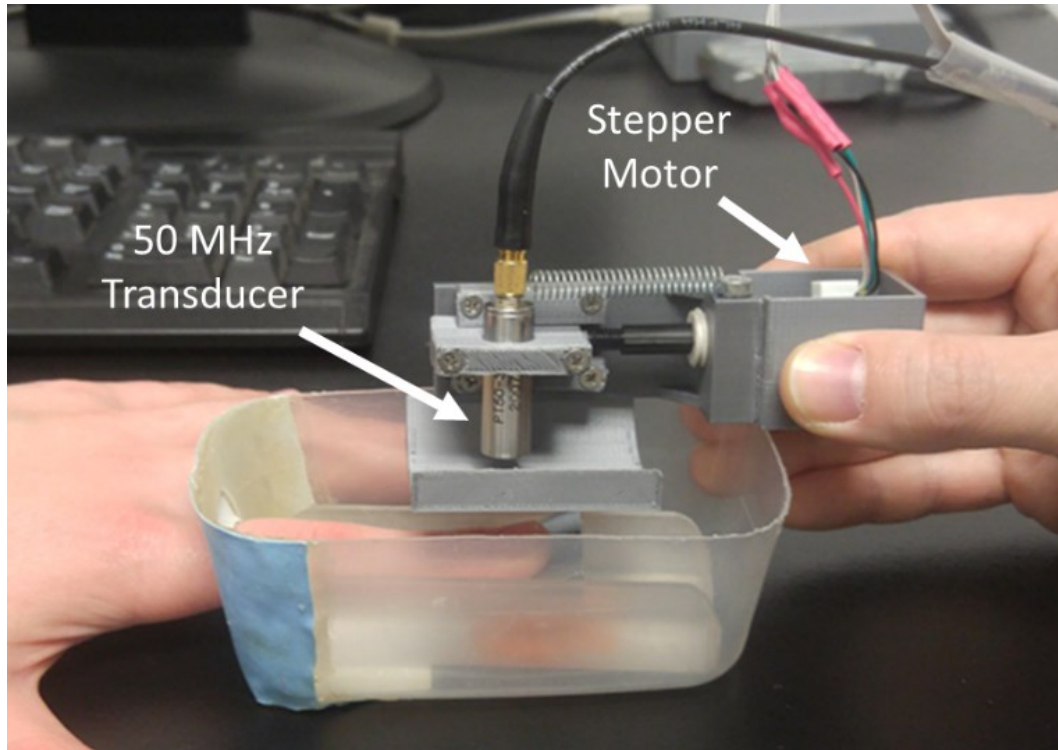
Ultrasound prototype for fingernail assessment in data collection. The 50 MHz transducer was attached to a 3D printed carcass and a spring-loaded stepper motor to allow B-scans to be taken longitudinally across the fingernail. A container was also made so that the fingernail can be inserted and submersed in water to act as the impedance matching layer to the transducer.
